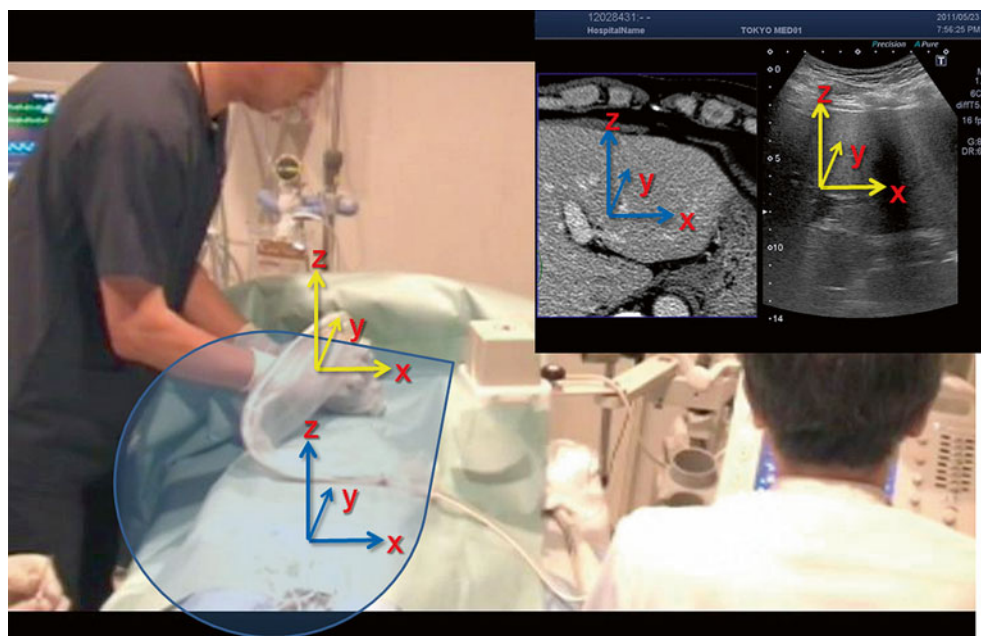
Fusion technology. The fusion technique displays both a CT image and an ultrasound image simultaneously
